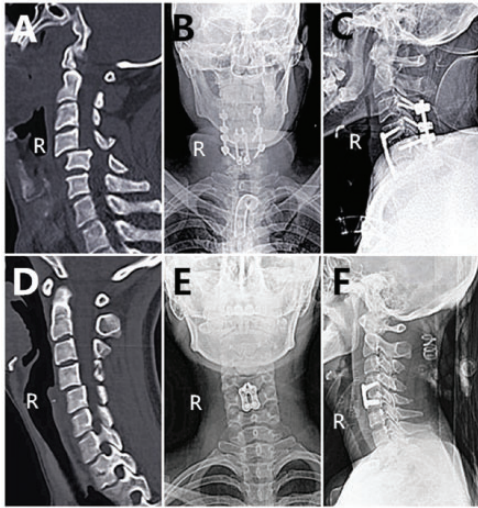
Surgical approaches. Preoperative radiographs [(A) sagittal; (D) sagittal]. Postoperative radiographs of two surgical approaches: combined anterior and posterior approach [(B) coronal; (C) sagittal] and anterior approach [(E) coronal; (F) sagittal]. Informed consent was obtained from the patient.
